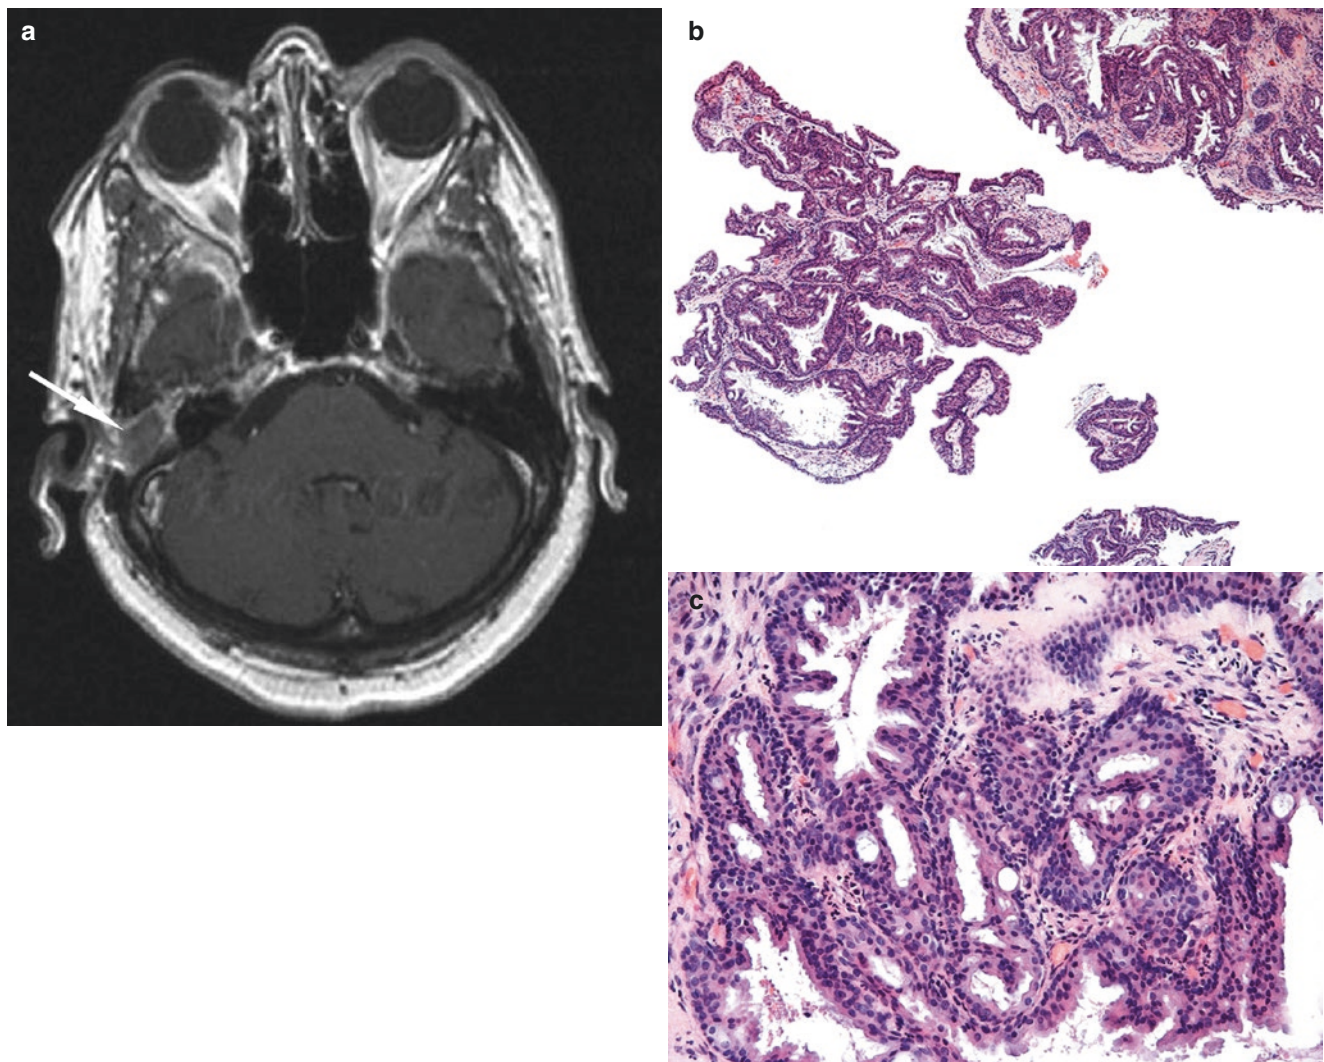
Aggressive papillary tumor of middle ear. (a) In the axial slice MRI scan, the *arrow* indicates a tumor confined to the middle ear that is not extending into the middle or posterior cranial fossae. (b) Tumor with papillary-glandular pattern and complex interdigitating
